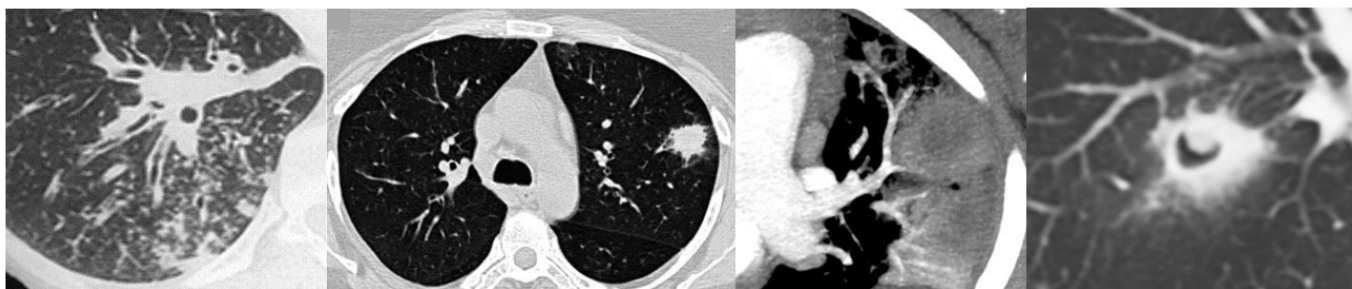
CT evolution of invasive pulmonary aspergillosis in a neutropenic patient. Early lesions show a macronodule with halo sign (hemorrhagic infarction); later findings include dense consolidation and eventual air-crescent sign with neutrophil recovery.
